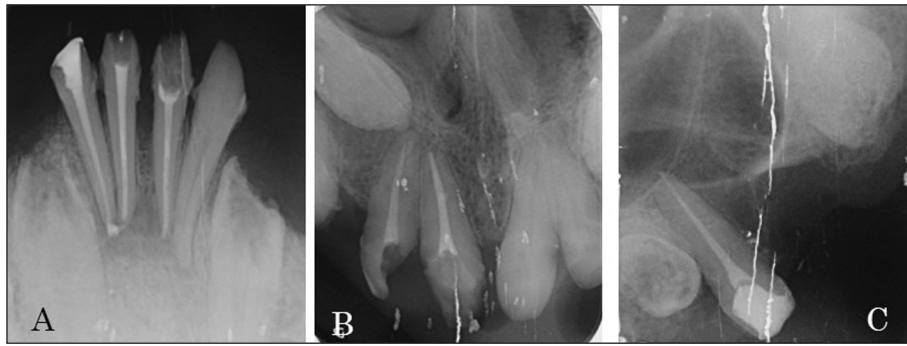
The image of periapical radiography after root canal treatment; A: Mandibular right-left central and right lateral incisor teeth, B: Maxillary right central incisor tooth, C: Maxillary second premolar tooth.
